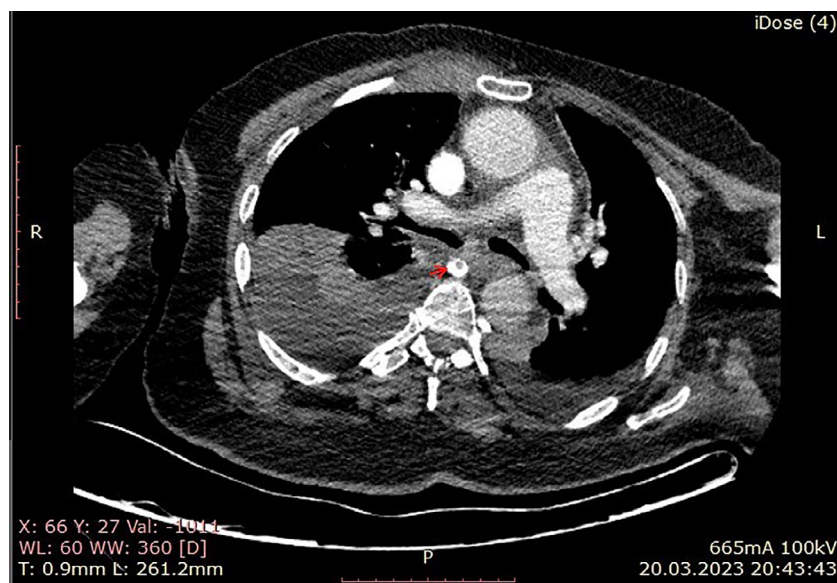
Mediastinal window of an axial section of a contrast enhanced thorax CT shows bilateral pleural effusions, especially more on the right hemithorax. Red arrow shows thrombosis in azygos vein
